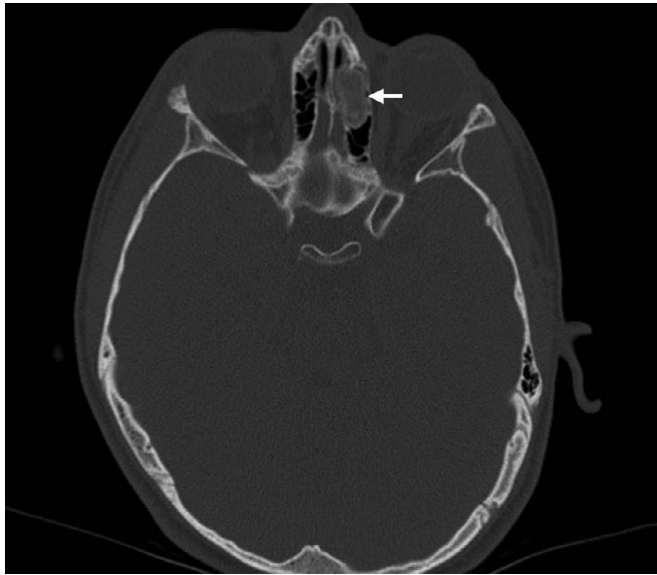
Sinonasal ossifying fibroma. Axial computed tomography shows an ossifying fibroma of the left ethmoid sinus (arrow). A thin “eggshell” calcific rim surrounds a fibrous center.
